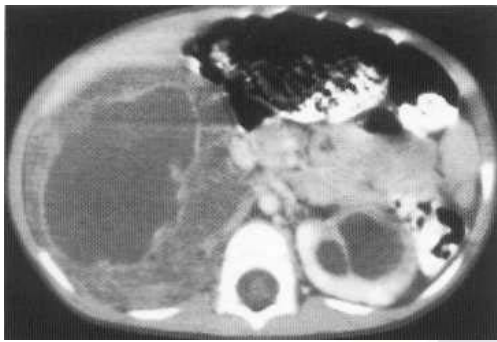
CT scan of bilateral Wilms' tumours showing an irregular multicystic appearance.
